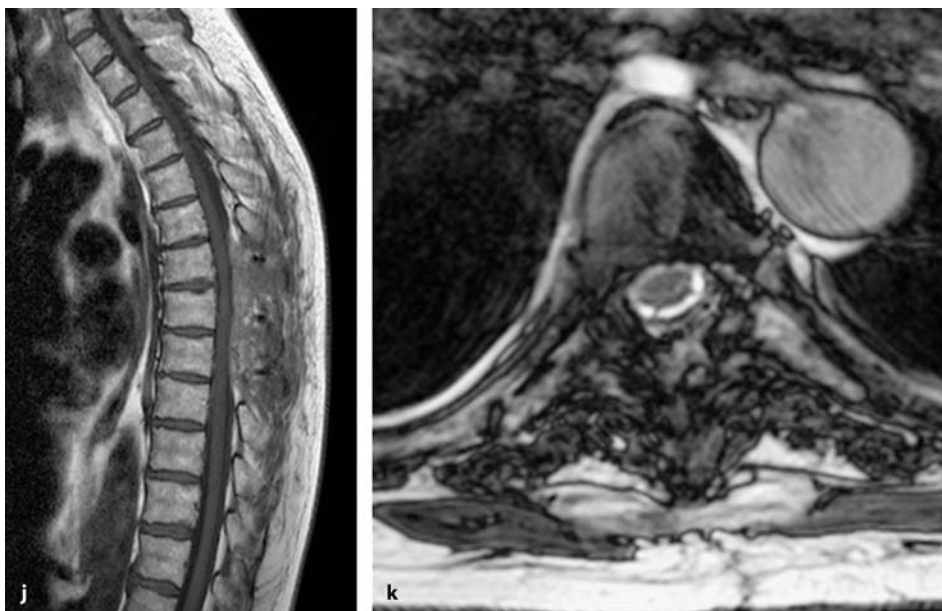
Sagittal (a) and axial (b) T1-weighted, contrast-enhanced MRI scans of a meningioma at Th6–Th7 in a 65-year-old woman with a 2-year history of pain and progressive paraparesis. c This coronal T2-weighted scan indicates the tumor position on the left side of the cord. d This intraoperative view, taken after dura opening, shows the tumor compressing
